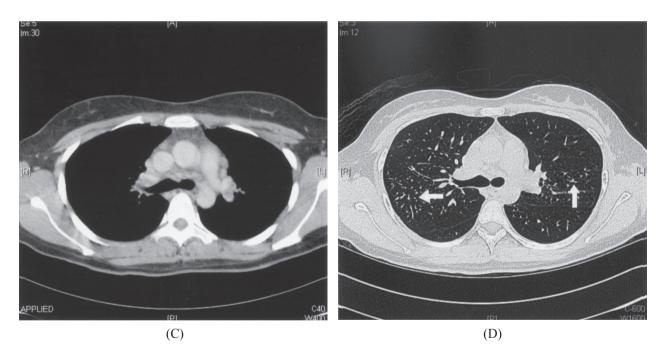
High resolution computed tomography (HRCT) of the lung with contrast. (Panel A) The image shows mediastinal lymphadenopathy. (triangle) (Panel B) Multiple bronchovascular bundle-disseminated military nodular lesions were found. (white arrow) These nodules are prominent in the right middle and lower lung fields and their sizes vary from 1 mm to 5 mm. After treatment (Panel C), the mediastinal lymphadenopathy showed improvement. (Panel D) Multiple disseminated miliary nodular lesions persist. (white arrow) Better pulmonary miliary nodules are found after treatment.
